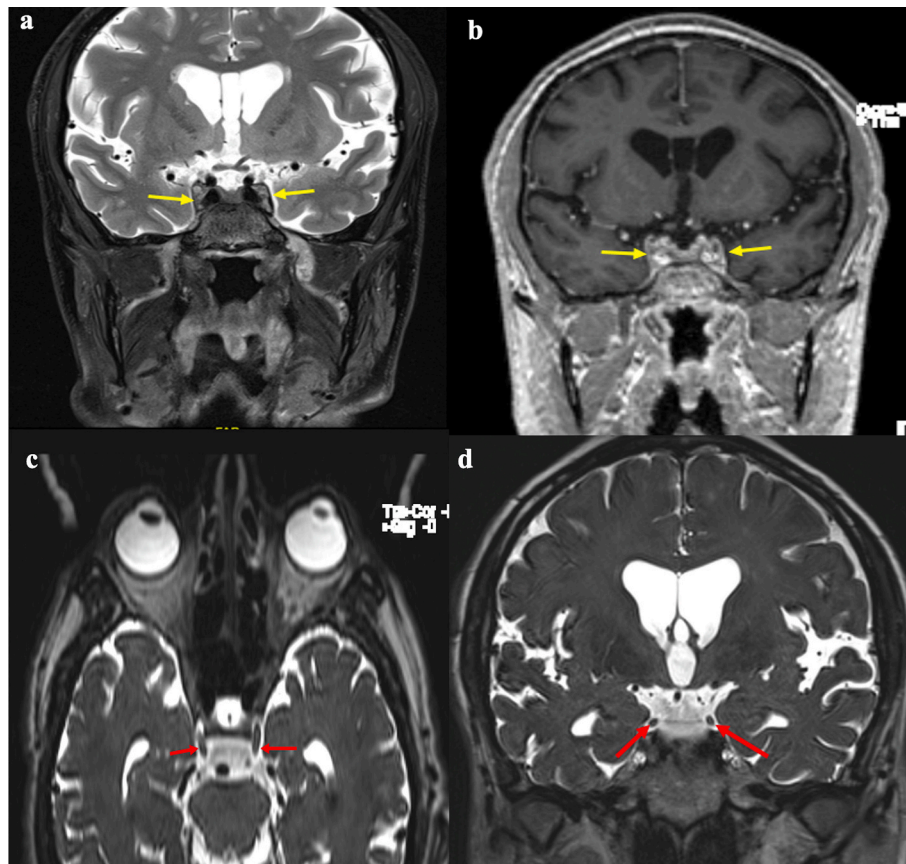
MRI brain of the patient: a) Coronal STIR and b) post contrast T1 images depicting bulky cavernous sinuses bilaterally with convex margins (yellow arrows). c) Axial and d) Coronal heavily T2 weighted images showing enlarged oculomotor nerves (CN III) in interpeduncular cisterns (red arrows) just before their entry into the cavernous sinuses.
